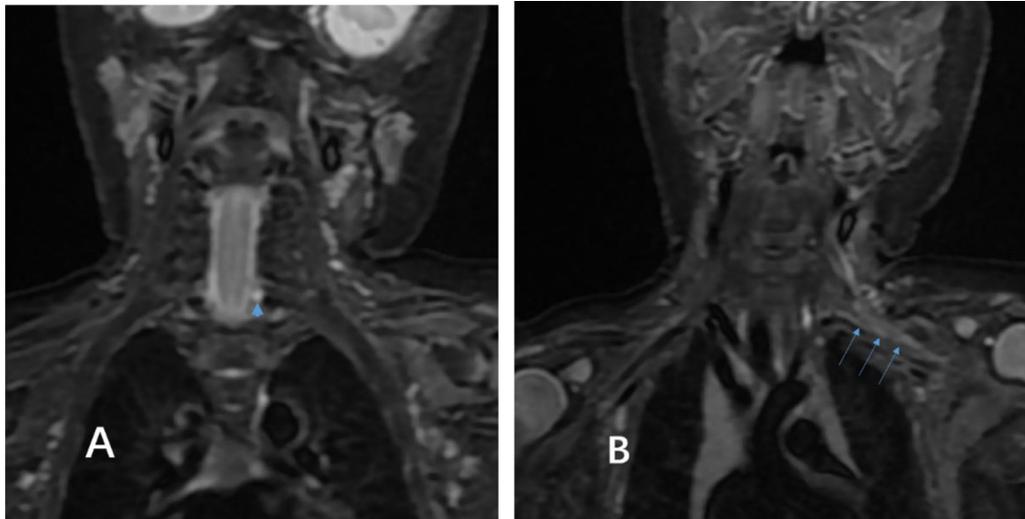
Coronal T2-STIR MRI sequence (A) centered a pseudomeningeal cysts (short arrow) on the left side at the level of C7; (B) revealed a thickened, swollen, and tortuous spinal root at the extraspinal segments of C5–T1 (long arrow) on the left side, with a high signal intensity.
